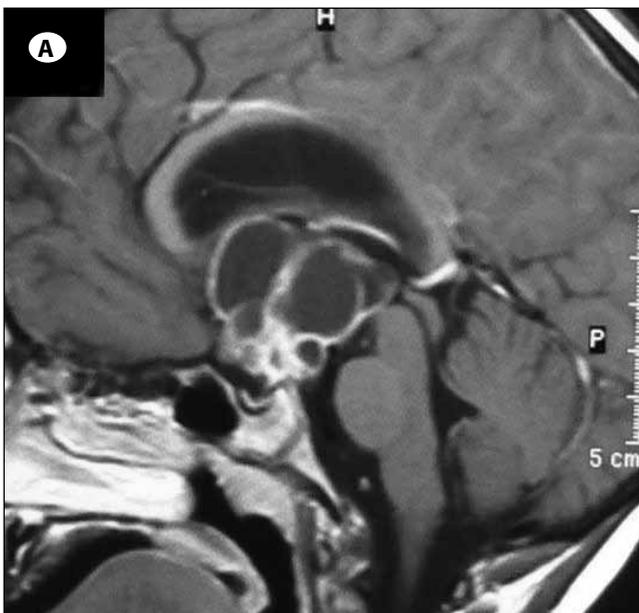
A) Sagittal contrast-enhanced T1-weighted MRI images demonstrate a heterogeneous tumor with solid component and cystic masses in the supra-sellar and partially intra-sellar space causing the compression of the floor of the third ventricle. B) No tumor recurrence is seen five years after surgery.
